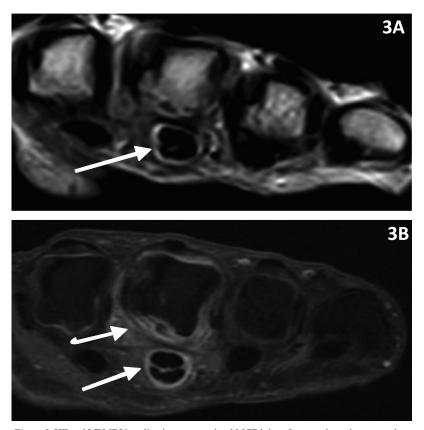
HF and LF MRI baseline images proximal MCP joints. Images show the comparison between images for tenosynovitis third MCP (arrow) and synovitis MCP3. (A) Patient 1 baseline post-GAD LF proximal MCP, T1 post-GAD non-fat-suppressed image (synovitis score 0, tenosynovitis score 1). (B) Patient 1 baseline HF post-GAD proximal MCP, T1 post-GAD fat-suppressed image (synovitis score 1, tenosynovitis score 2). HF: high-field; LF: low-field; MRI: magnetic resonance imaging; MCP: metacarpophalangeal; GAD: gadolinium.
